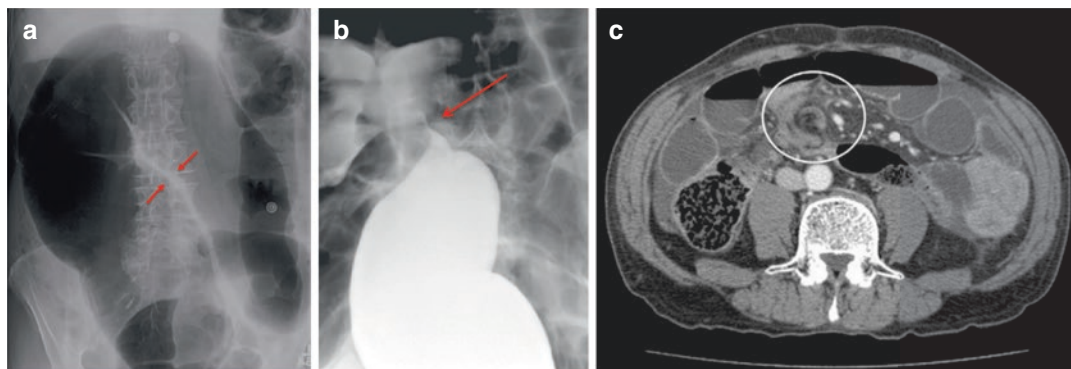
Characteristic imaging findings for sigmoid volvulus. (a) “Coffee-bean” sign on plain radiograph. Note the thick inner wall, representing a double-layer of apposed bowel wall (red arrows). (Reused with permission © 2015 Springer) (b) “Bird’s beak” sign with rectal
